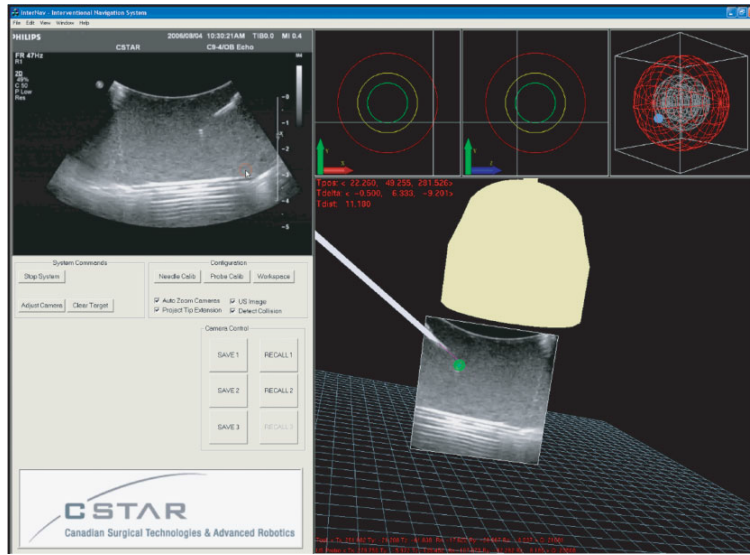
Graphical user interface for ultrasound navigation [99].
